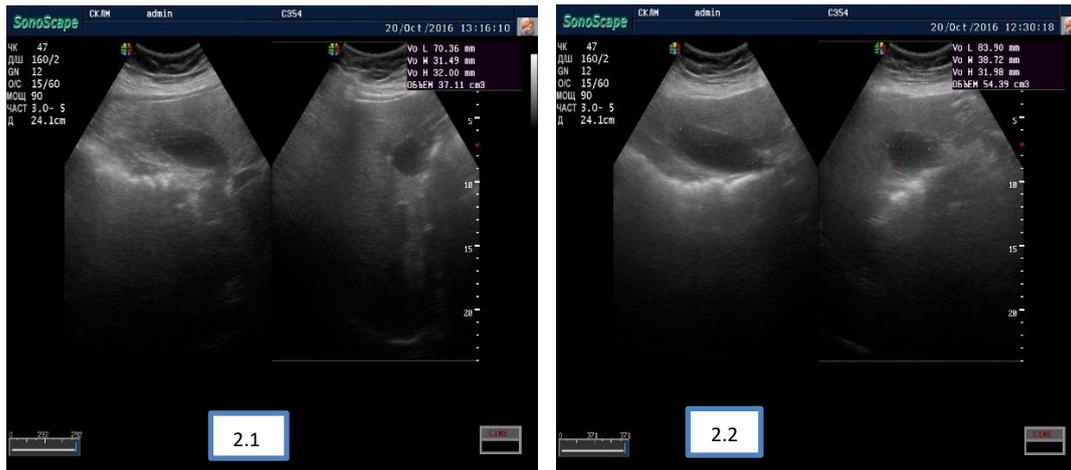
Ultrasound images of the gallbladder before (Fig.2.1.) and 40 minutes after(Fig2.2.) fatty meal. The gallbladder sizes and volume values calculated from the ultrasound images (ejection fraction 37%).
